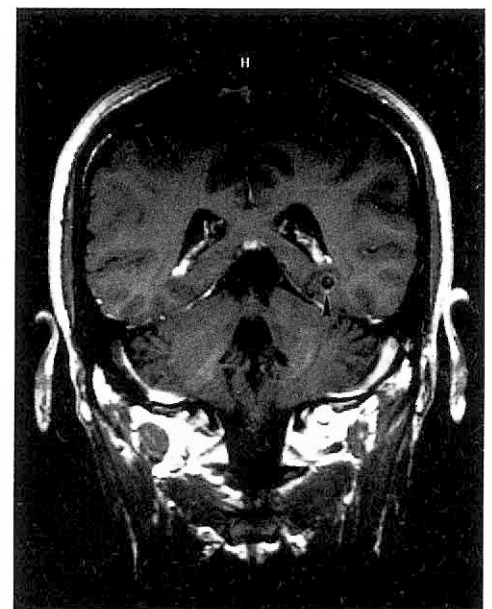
Follow-up MRI after treatment of the same patient in Fig 1 shows that the lesion has entered the granular nodular stage where the cyst has become smaller in size, the wall is now thicker and more intensely enhancing, and the mural nodule has disappeared (arrow).
